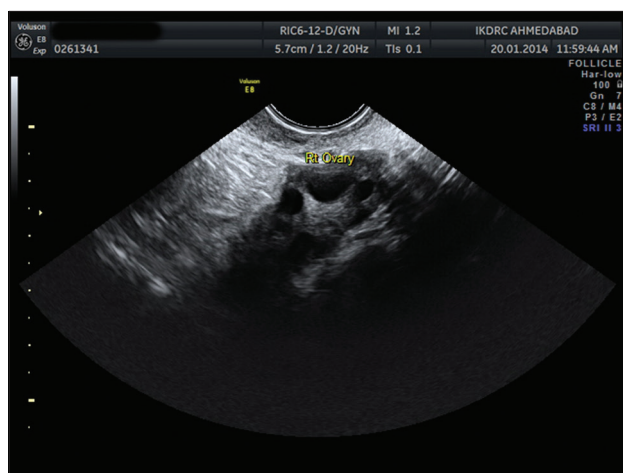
Transvaginal sonography showing normal right ovary with antral follicles
